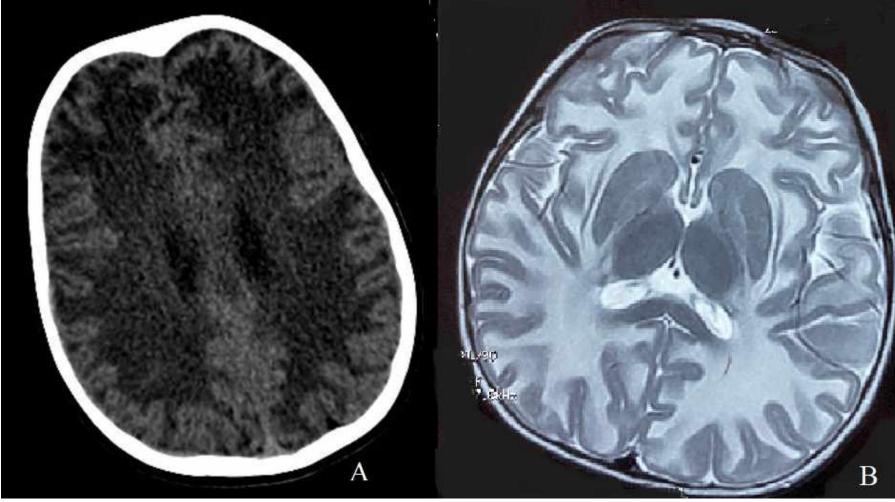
A) Axial CT scan that showed prominent diffuse white matter hypodensity, B) Axial: FLAIR image reveals diffuse bilateral symmetrical white matter hyperintensities
